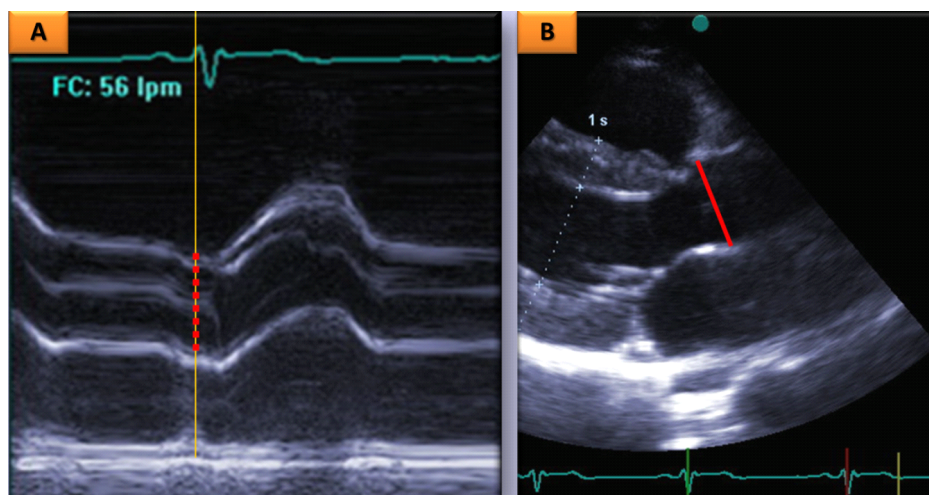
Echocardiography mode M (A) and 2D (B). Techniques for measuring aortic root at the sinus level of Valsalva.
